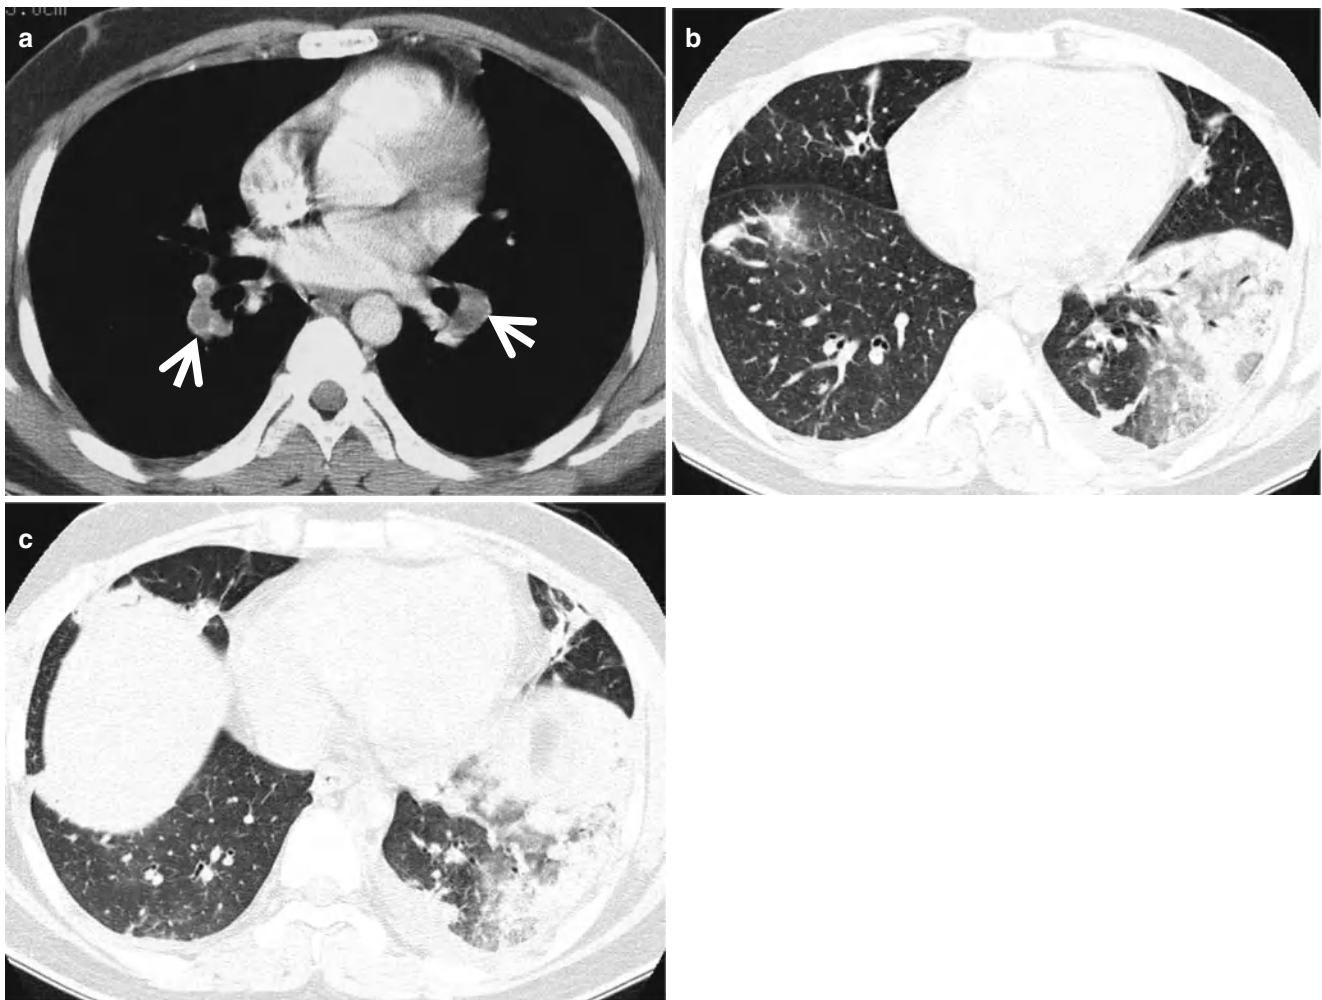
Pulmonary embolism and consequent lung infarction in a 32-year-old man with chronic liver disease and deep vein thrombosis. (a) Enhanced CT scan (5.0-mm section thickness) obtained at level of basal trunks shows filling defects (arrows, embolism) in the bilateral lower lobar pulmonary arteries. (b, c) Lung window images of CT
